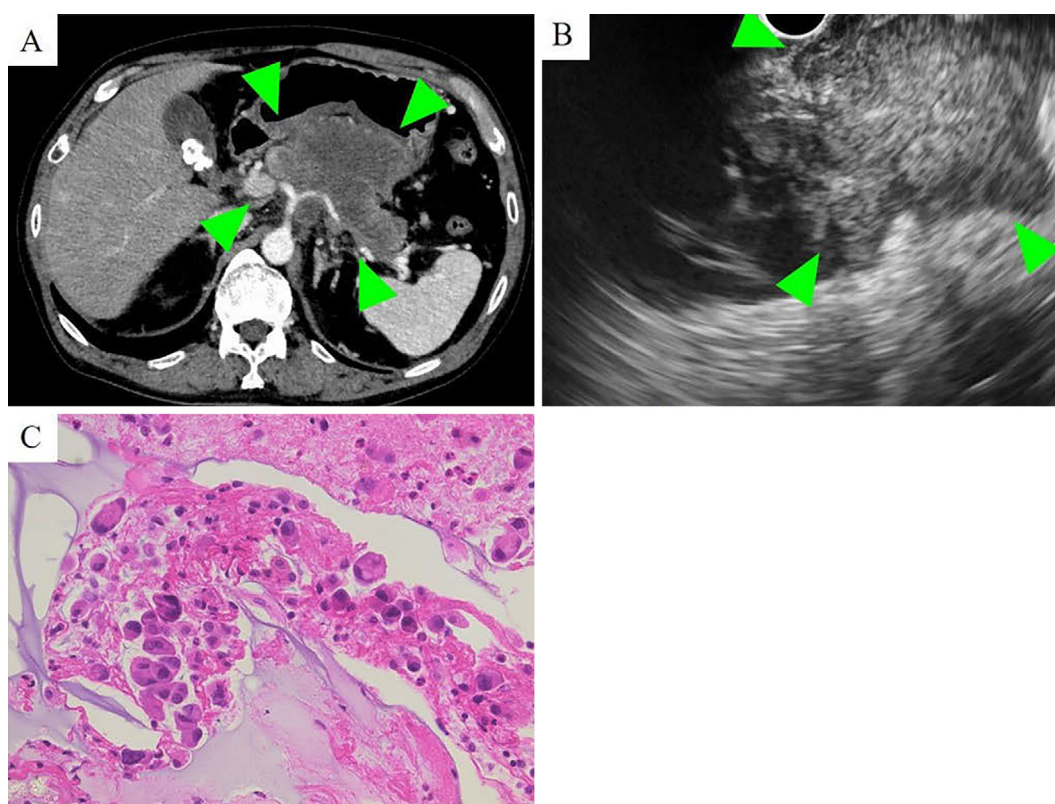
Contrast-enhanced computed tomography images at our hospital on day 1. An 85×85 mm low-density pancreatic tumor with high density area on the periphery of the tumor had spread to organs near the pancreas, such as the liver, stomach, celiac artery, portal vein and superior mesenteric vein (A). Endoscopic ultrasound revealed a hypoechoic mass with irregular margins (B). Pathological findings showed numerous atypical cells, suggesting poorly differentiated carcinoma (C).
